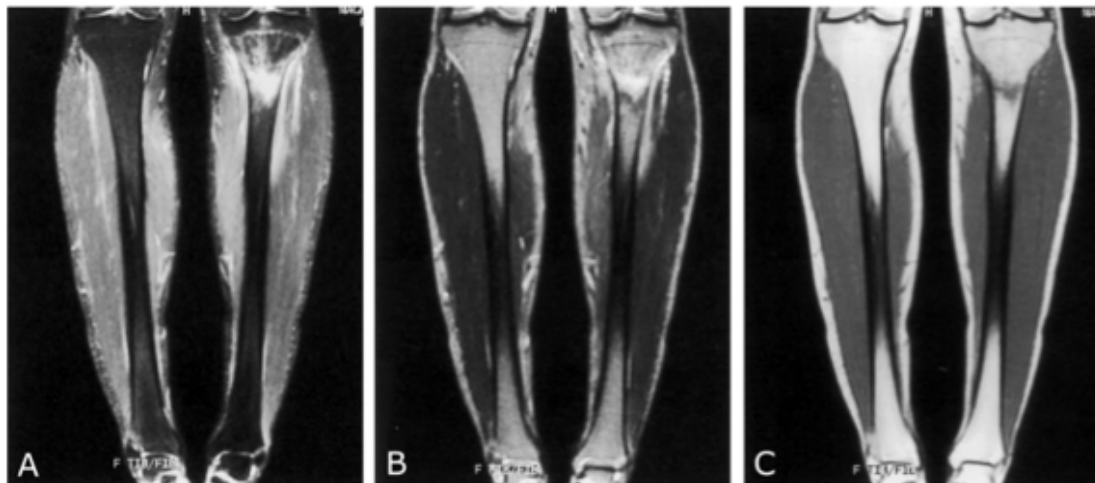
Three different weighted coronal MRI sequences of a female runner's tibia.
